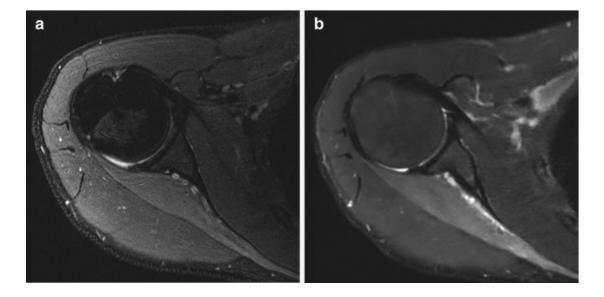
A 29-year-old man with suprascapular nerve entrapment at the suprascapular notch. Axial (a) fat-suppressed and (b) water-image IDEAL T2-weighted MRI show muscle edema is more visible on image b for different reasons: the signal-to-noise ratio is better and the signal homogeneity is better. However, the spatial resolution is lower on image b
